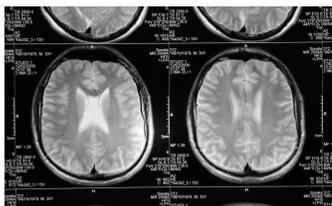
MRI Scan of Healthy Brain vs. PTSD Afflicted Brain.⁷
